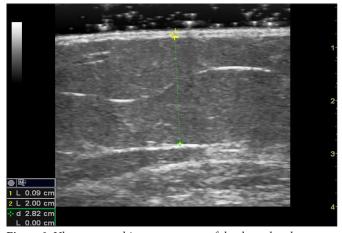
Ultrasonographic measurement of the dermal and subdermal thickness of the thigh
